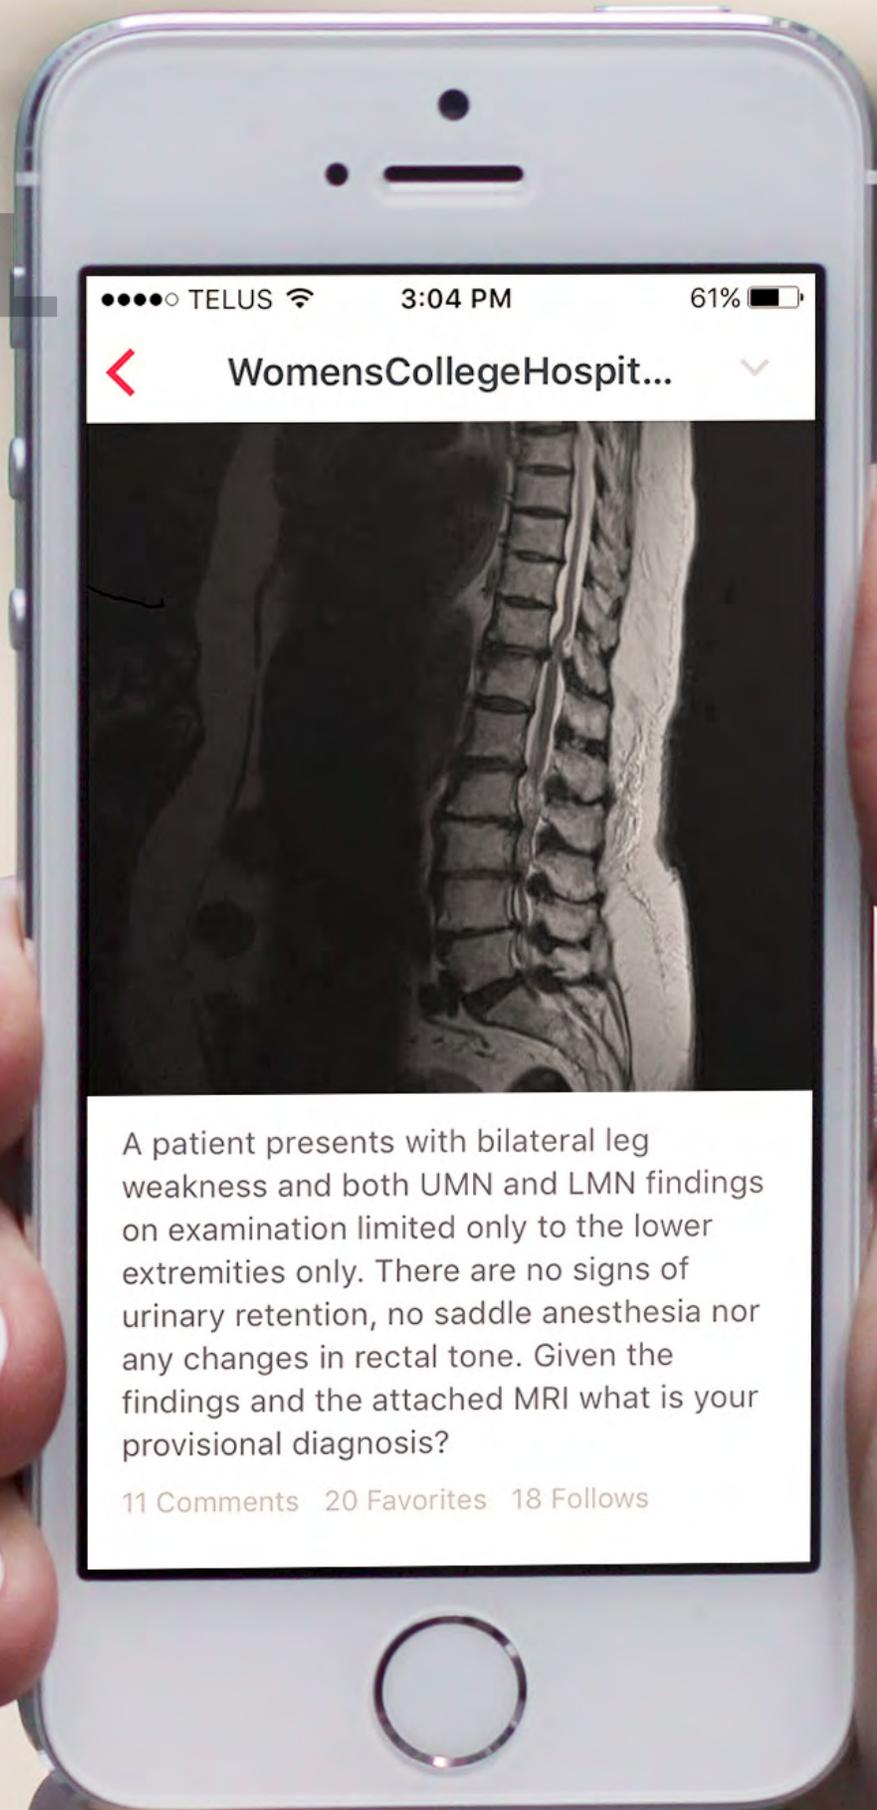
has created an app that can be downloaded for free on phones and tablets to allow subscribers to view anonymous images of wounds or even X-ray results taken with patient consent. Healthcare providers can easily view images and share their comments, views and experiences managing different approaches to treatment.
